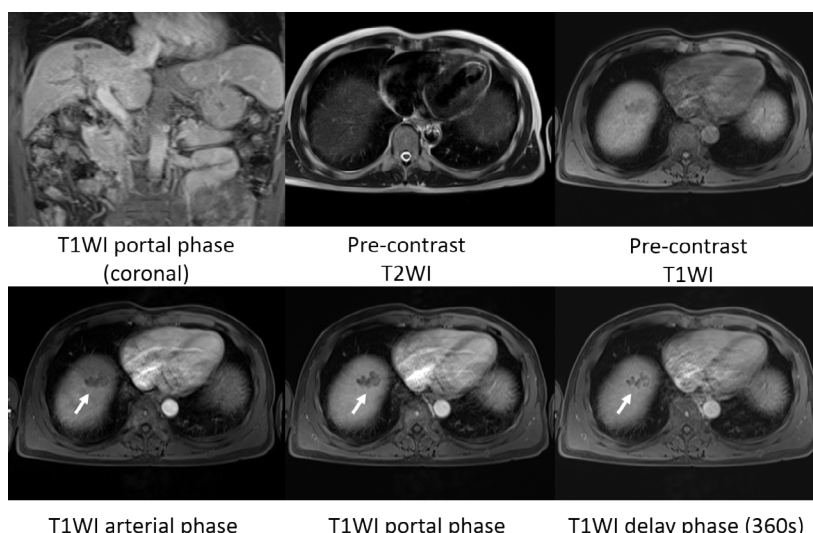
Post follow up MRI images showed good response without hypervascular tumor (white arrows).
